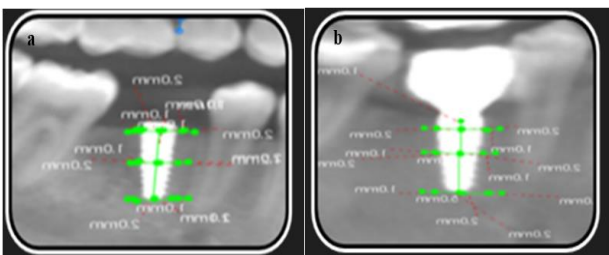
(a) Measuring bone density around implant at baseline through CBCT, (b) measuring bone density around implant at 9 months of implant placement through CBCT.
